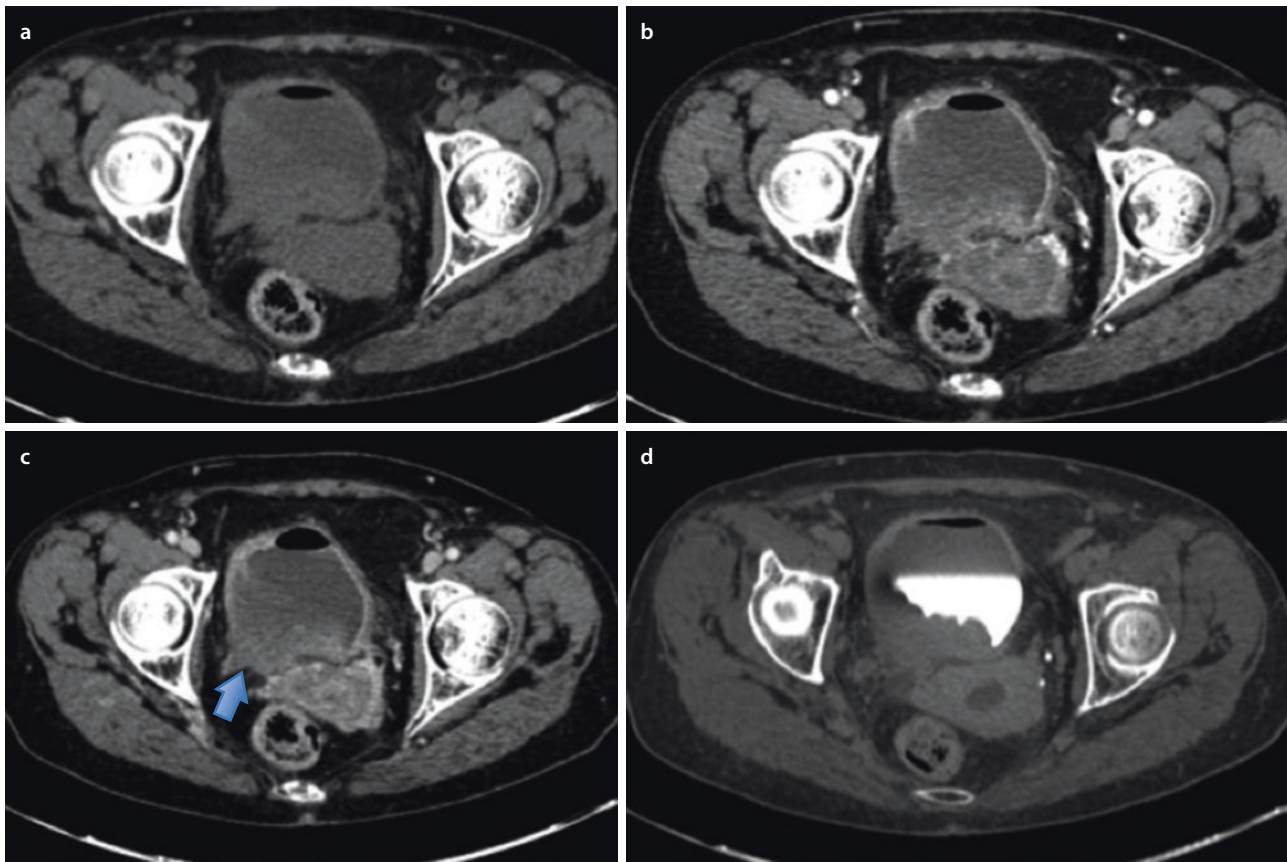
CT examination of a patient affected by bladder cancer with irregular margins (arrow in C). a, pre-contrast image; b, arterial phase; c, portal venous phase; d, pyelographic phase
